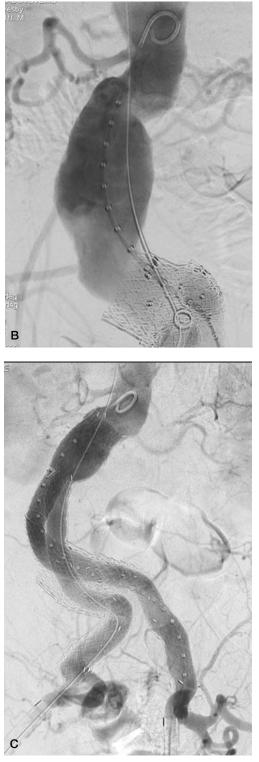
a-b. CT angiogram and aortogram of distal migration of Aneurx device. c. Successful AAA exclusion following placement of entire secondary endograft.
